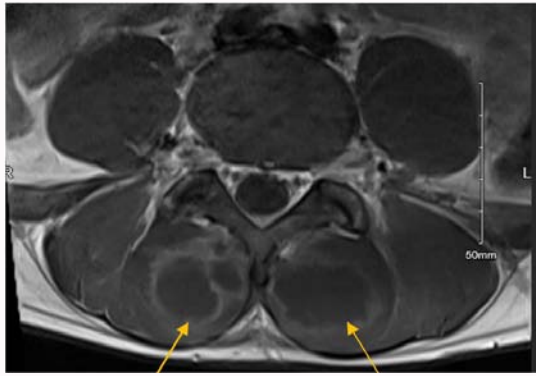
Hospital day 0 MRI of the lumbar spine showing bilateral paraspinal abscesses (see arrows).
